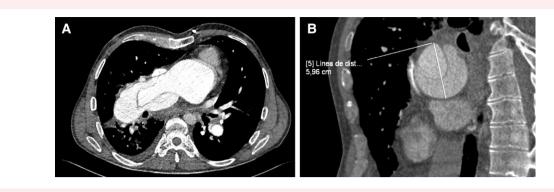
Urgent computed tomography scan showing acute right pulmonary artery dissection: transversal (A) and sagittal (B) sections.
